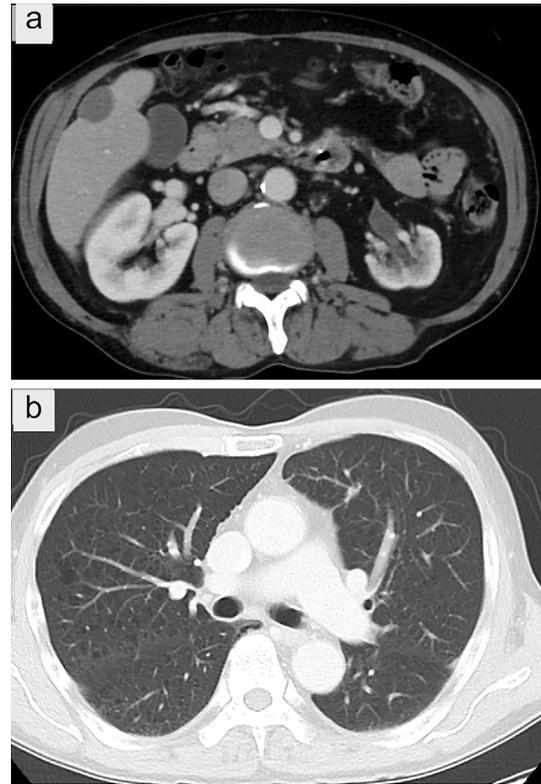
Regression of the lesions demonstrated on computed tomography. (A) Hepatic lesions regressed in size from 45 to 23 mm. (B) Lung lesions achieved almost complete remission. Please see Figure 1 for the comparison.
